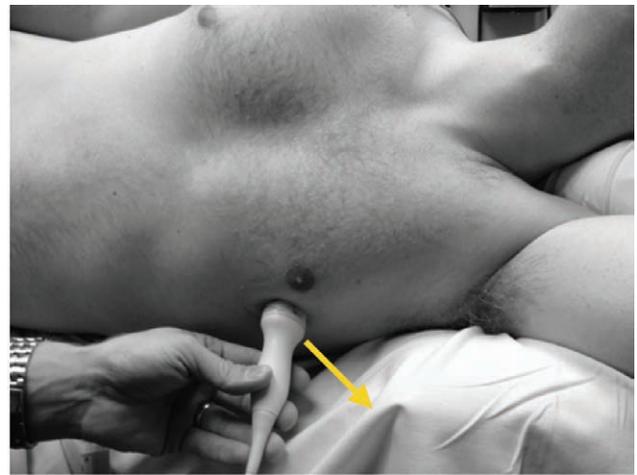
Probe position for the apical 4 chamber. The patient is in the left lateral decubitus position with their left arm extended. The probe is located just inferior and lateral to the left nipple, with the indicator pointed toward 5 o'clock (as viewed from above.) The indicator location and direction is shown by the yellow arrow.
